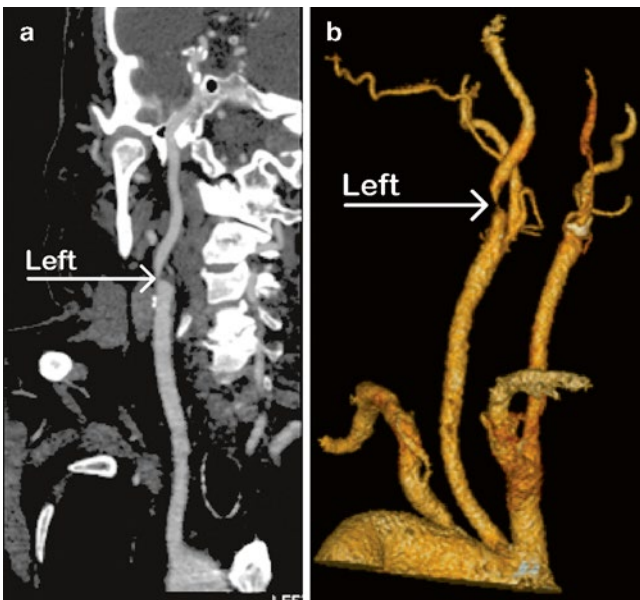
CTA showing (a) severe left proximal internal carotid artery stenosis (*arrow*); (b) same patient showing aortic arch vessels (*arrow*)
